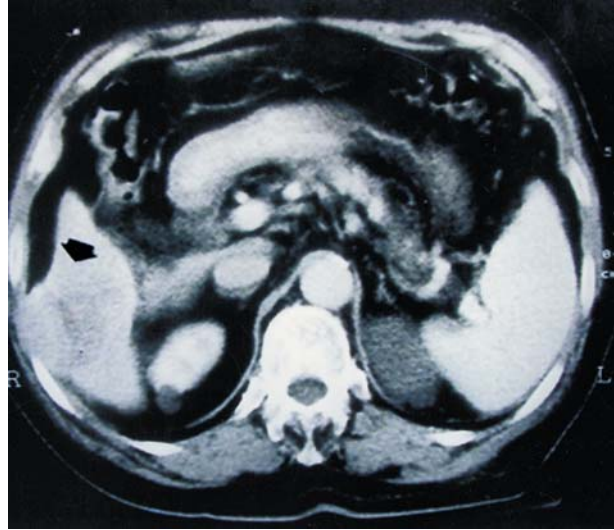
Abdominal computed tomography shows a 6.5-cm tumor at the right lobe of the liver (arrow).
